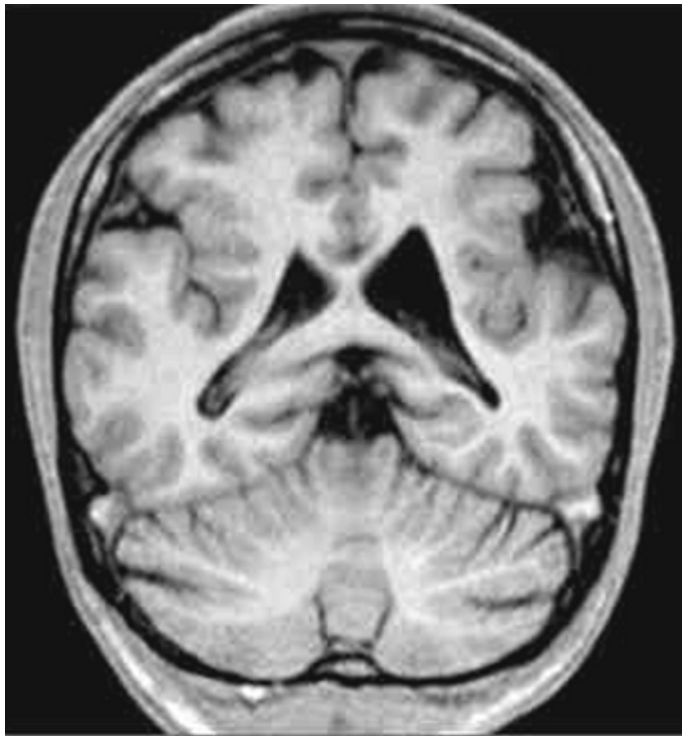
Polymicrogyria (PMG), bilateral perisylvian syndrome. Coronal T1- weighted magnetic resonance image shows bilateral perisylvian PMG.
